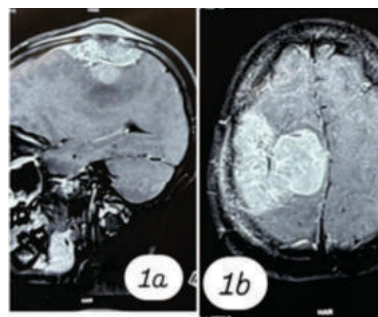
MRI brain with contrast: (a) sagittal and (b) axial sections demonstrating a contrast-enhancing dural-based lesion in the right parietal region
